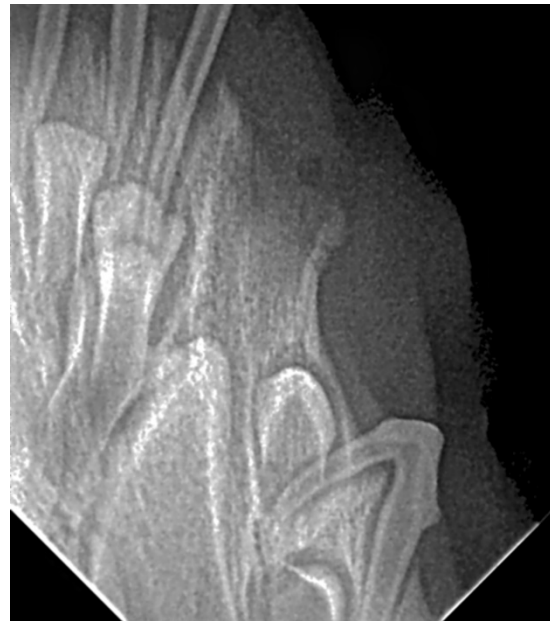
The required post-op radiograph.
